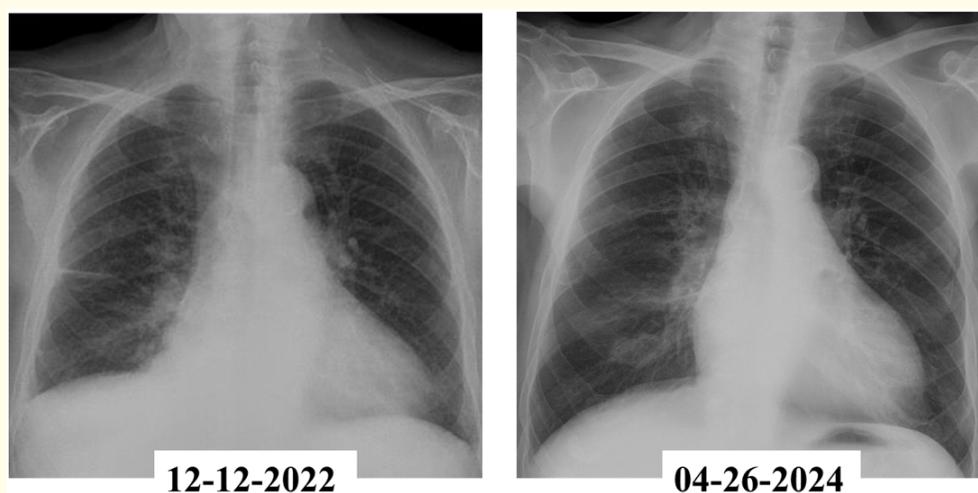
Chest X-rays taken before and after using the double focal compression bandaging technique reveal a noticeable improvement in the size of the cardiac chambers following the compressive therapy.
